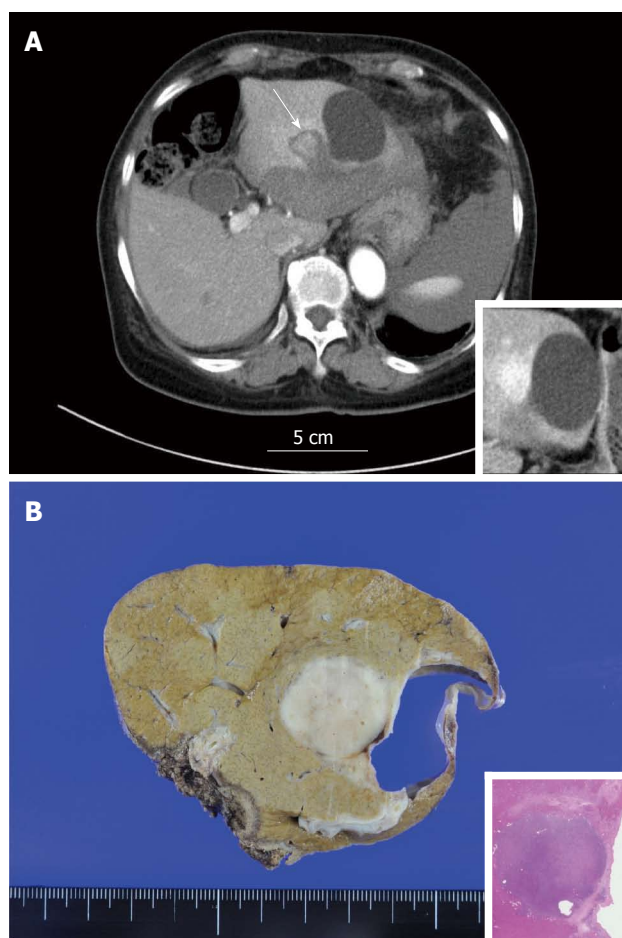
Computed tomography. A: Contrast-enhanced abdominal CT on admission. Subcapsular hematoma at the left lobe of the liver and hemorrhagic ascites around the spleen were observed. The mass-like lesion measuring approximately 1.5 cm is also visible at segment 2 of the liver adjacent to the simple hepatic cyst (arrow). Inset: CT taken two months after onset. The nodule was highly enhanced by contrast medium in the early phase; B: The cut section of the nodule. A well-demarcated brown to whitish solid mass lesion measuring 2.5 cm in diameter was observed. A simple hepatic cyst was adjacent to the nodule. Inset: loupe image of the nodule (HE). CT: Computed tomography.
